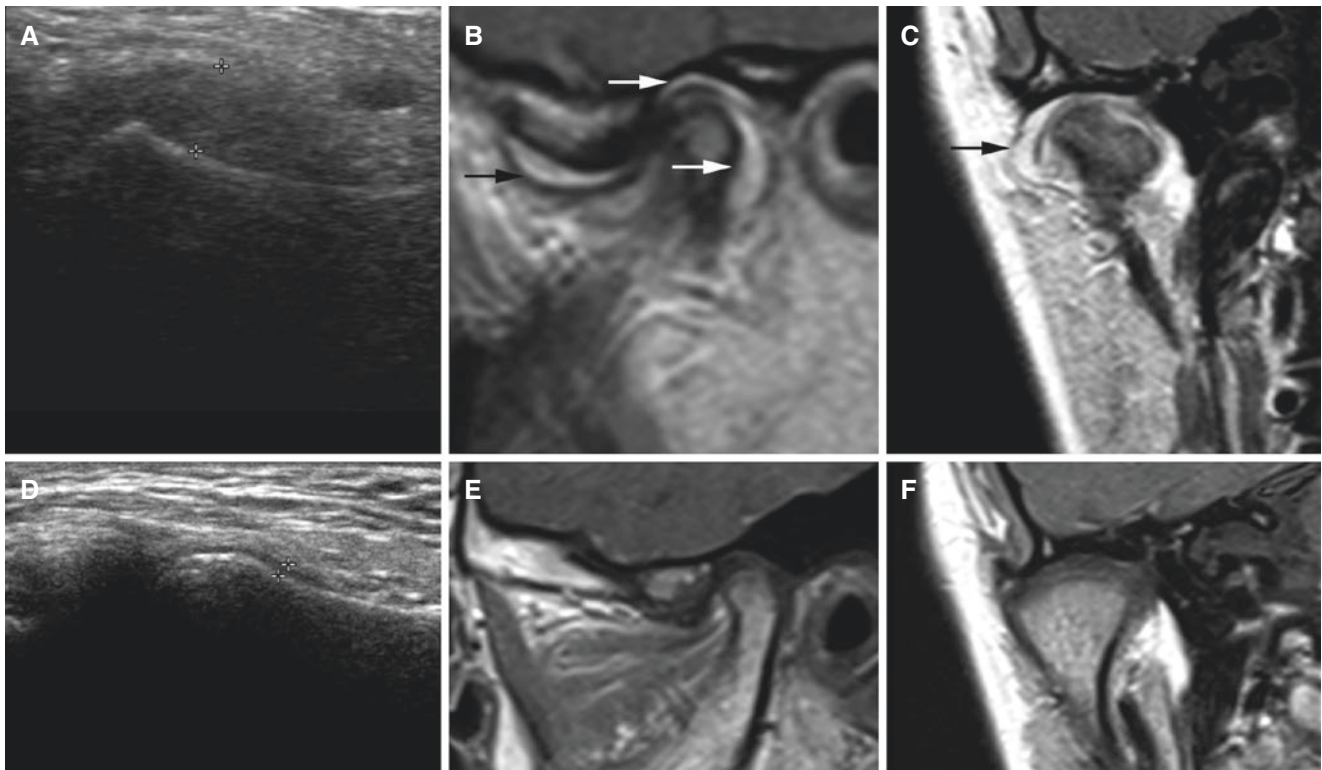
Juvenile idiopathic arthritis; 17-year-old female with contrast enhancement (synovitis) (A–C) and 10-year-old female without contrast enhancement (D–F). (A) Ultrasonography shows increased capsule width (distance measured to 4.3 mm). (B) Oblique sagittal and (C) oblique coronal T1-weighted post-Gd MRI show extensive contrast
